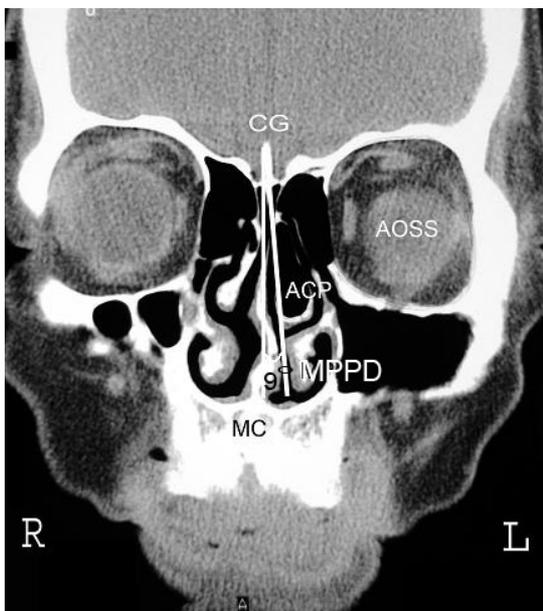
Coronal plane of paranasal sinus CT scan of patient with nasal septum deviation and contralateral CB. Deviation angle, AOSS, ACP and CBPI are 20°, 82mm², 625mm² and 13.1, respectively.
